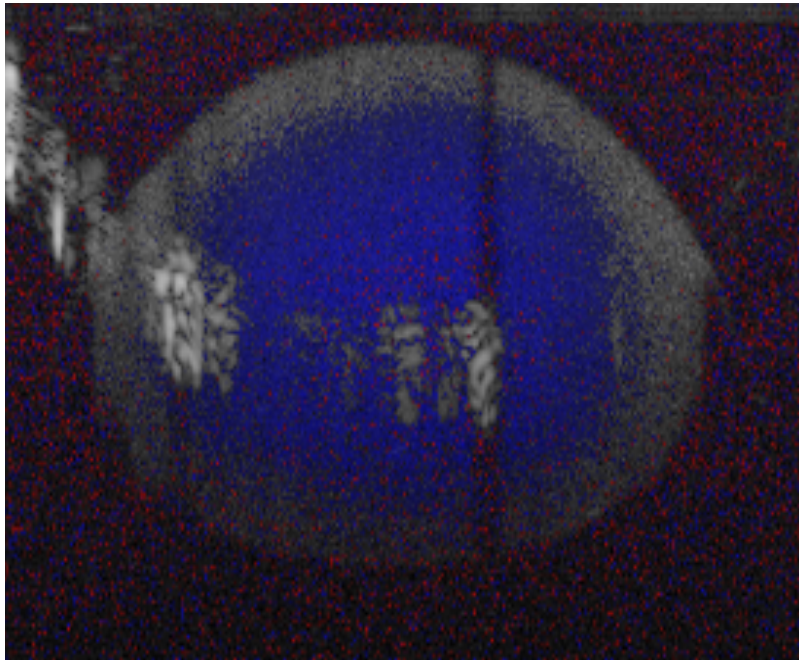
Doppler image of GNR solution flow field (0.7×10^{12} GNRs/mL)
